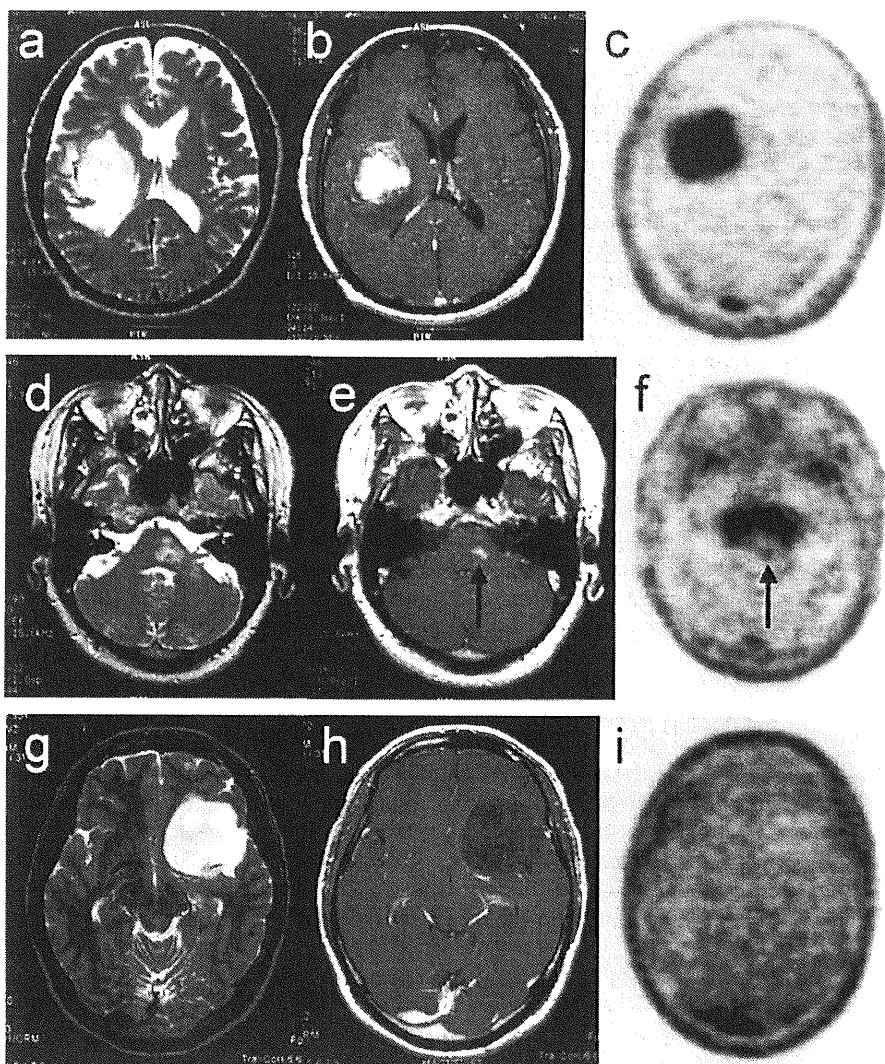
Representative cases of brain gliomas of differing grades. (a–c): A 75-year-old patient with glioblastoma. T2WI (a) shows a hyperintense mass lesion in the right cerebral hemisphere, which was strongly enhanced after the intravenous administration of Gd-DTPA (b). FLT-PET (c) shows very high uptake of FLT (SUVmax = 6.07, TNR = 20.93) in the tumor. (d–f) A 60-year-old patient with grade 3 astrocytoma. T2WI (d) shows a hyperintense brainstem lesion with focal spotty enhancement (arrow) after Gd administration (e). FLT-PET (f) shows the focal accumulation of FLT (SUVmax = 1.00, TNR = 2.86) corresponding to abnormal enhancement (arrow). (g–i): A 36-year-old patient with grade 2 astrocytoma. T2WI (g) shows a hyperintense lesion in the left frontotemporal region without abnormal enhancement after Gd administration (h). FLT-PET (i) shows no visible accumulation of FLT (SUVmax = 0.49, TNR = 1.17) corresponding to the tumor.
